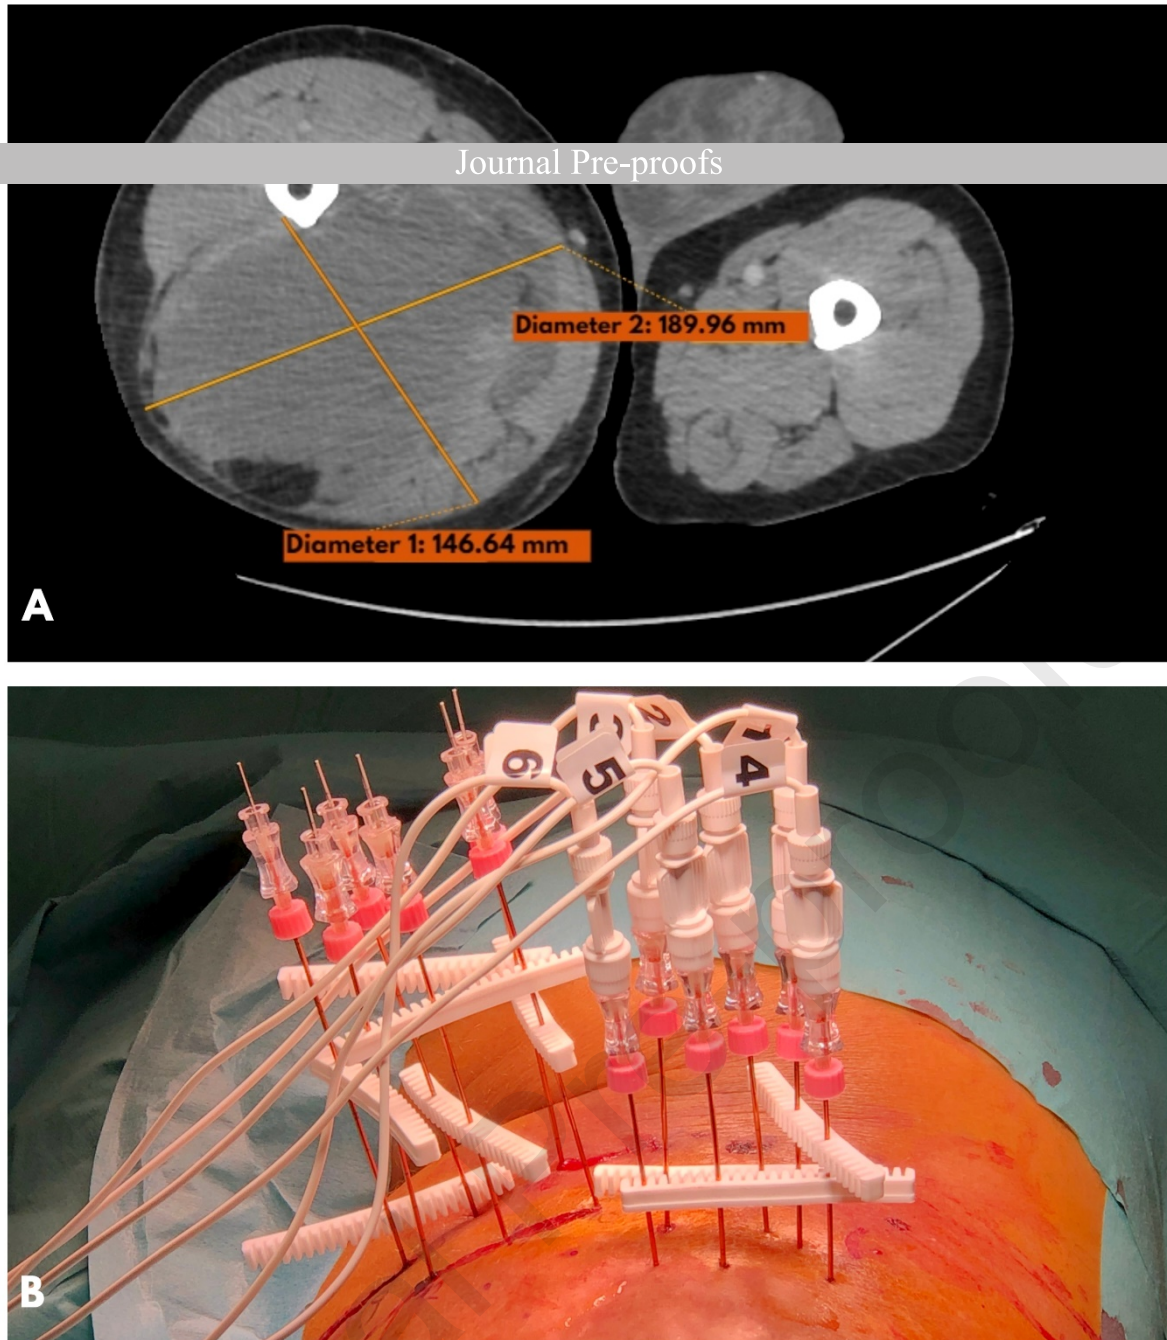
VEG ECT treatment of fibromyxoid sarcoma of the left lower extremity (thigh). A: MRI showing pretreatment extent of the sarcoma. B: electrode positioning during VEG ECT treatment. ECT: electrochemotherapy; MRI: magnetic resonance imaging
